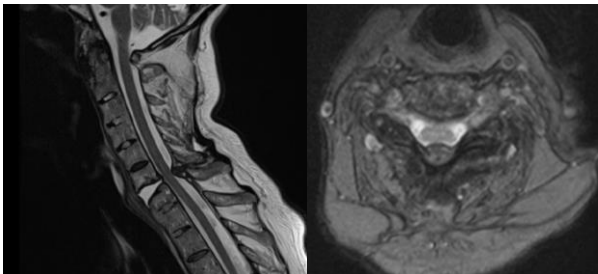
B. MRI confirms C6-C7 fracture, posterior ligament cord compression.
